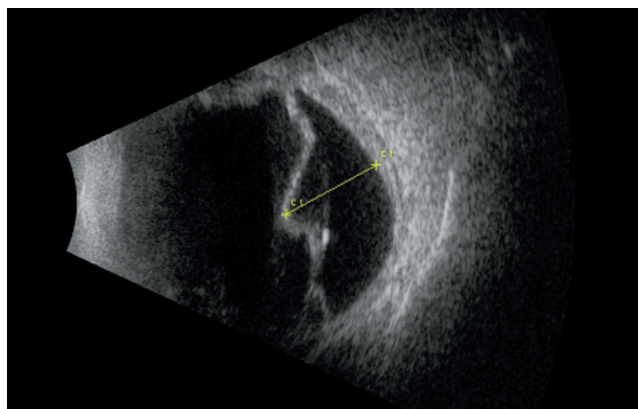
Ultrasound examination of the right eye 2 weeks after surgery: total retinal detachment is observed in all the meridians at the close, the middle and the marginal periphery with a retinal tear from the ora serrata at the 5–9 o'clock meridian, with a height of up to 8 mm, the retina is mobile.
